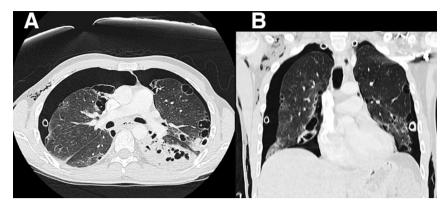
Follow-up chest CT. It shows an improvement in ground-glass opacities and consolidations areas with multiple cysts as new radiological findings. There could be seen both pneumothorax with both thoracostomy tubes and subcutaneous emphysema.
